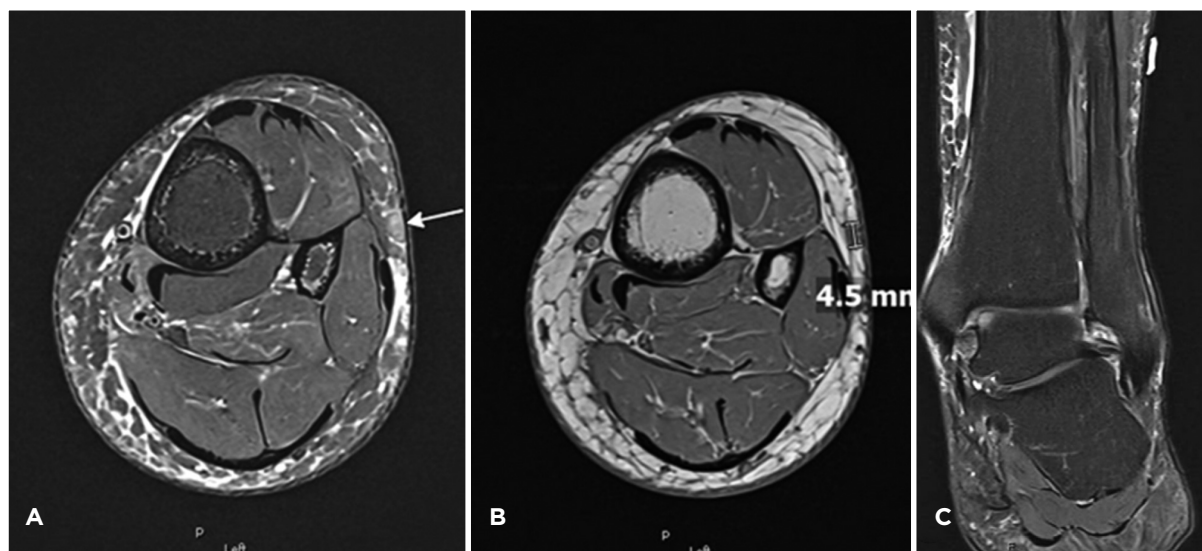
Angioleiomyoma finding. (A) Axial T2-weighted magnetic resonance imaging. (B) Axial T1-weighted magnetic resonance imaging. (C) Coronal T2-weighted fat-saturated magnetic resonance imaging.
